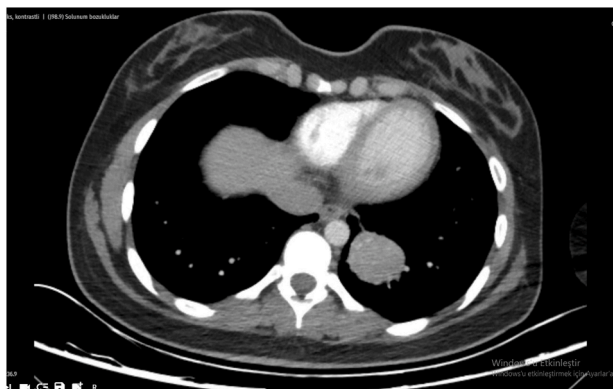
Chest CT imaging of patient - mediastinal window
